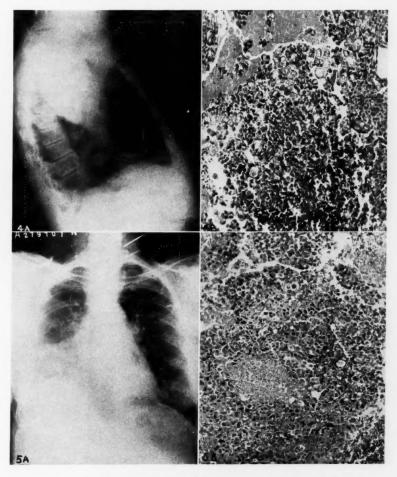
A. Lesion suggestive of interlobar empyema as seen in right lateral roentgenogram.
